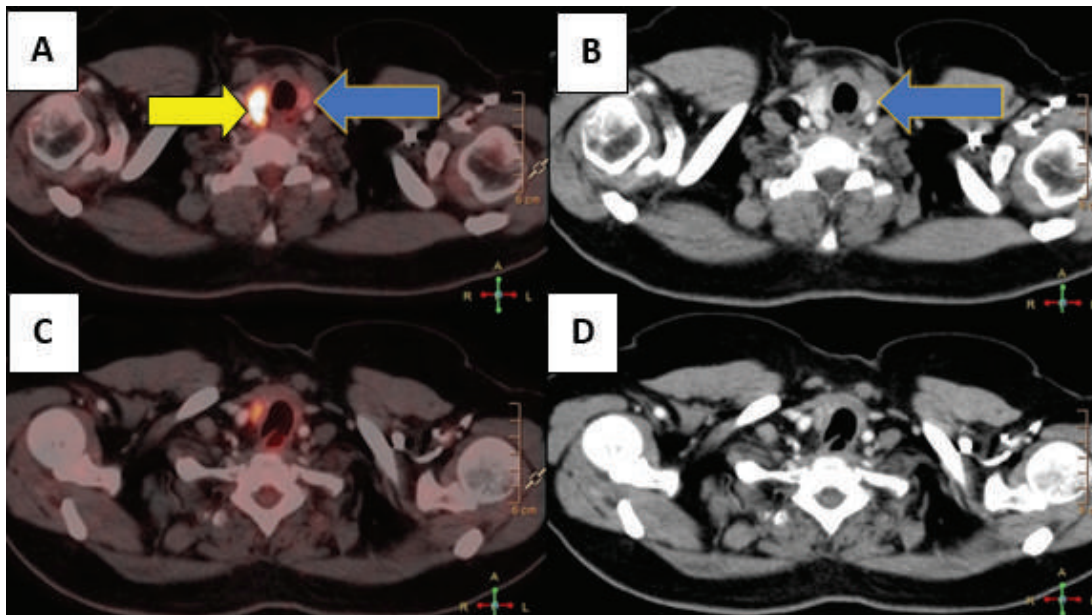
Post-therapy ^{18}F -FDG PET-CT fused axial images demonstrating complete morpho-metabolic regression of the previously noted thyroid mass (A, B, C, D), consistent with excellent therapeutic response. Residual diffuse FDG uptake (A, yellow arrow) in the right thyroid lobe is likely attributable to thyroiditis.
